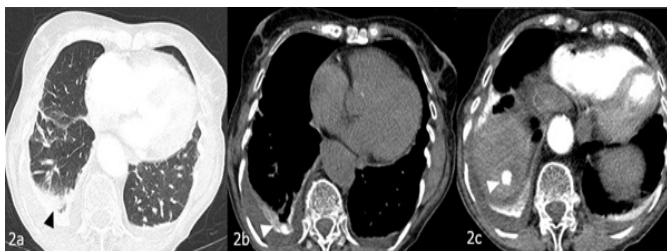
Chest CT-scan showing the presence of parenchymal dystelectasia (a) and radio-opaque material within the apical and posterior segment of the lower right lobe (b), as well as liver accumulation (c).
